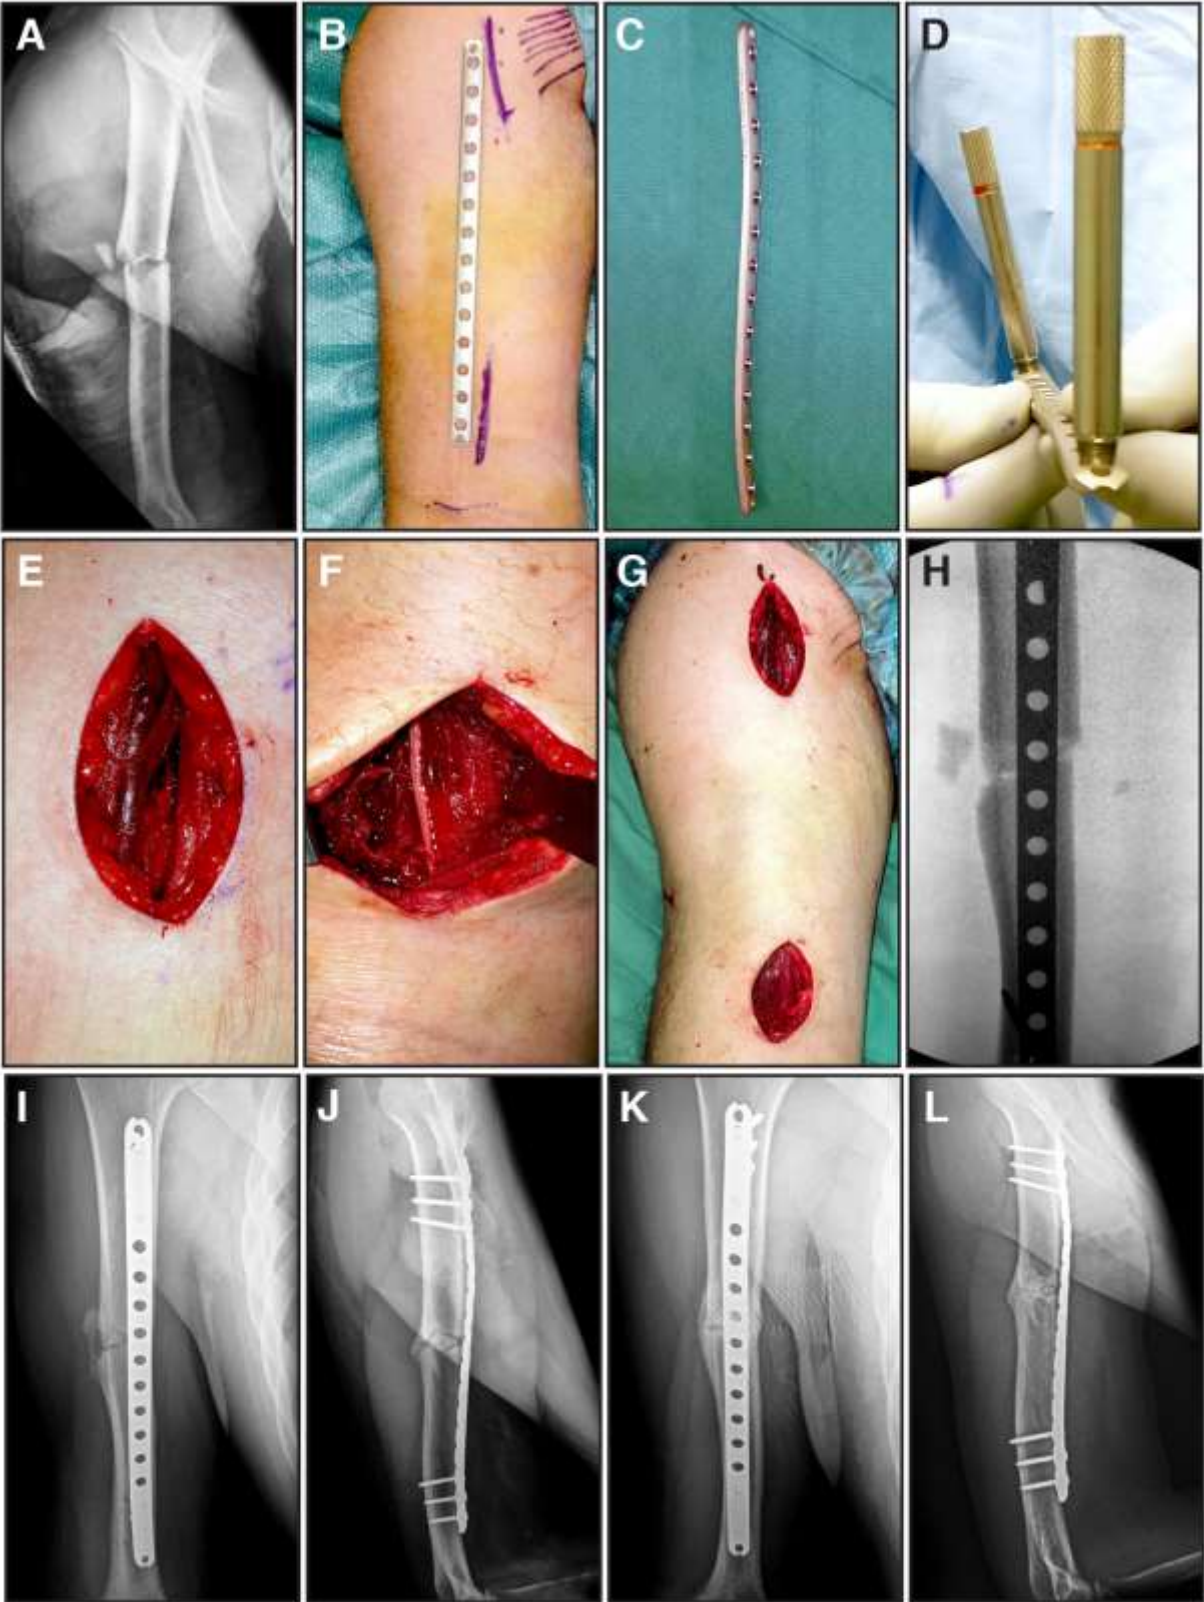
This 37 yo right hand dominant man sustained polytrauma in a motorbike accident. His injuries included a right floating elbow, with an ipsilateral both bone forearm fracture and (A) a closed mid-shaft right humeral shaft fracture; (B) a 14-hole locking compression plate was selected, with adequate length to span the fracture and provide sufficient mechanical control; (C) this plate was pre-contoured to closely match the normal anterior humeral cortical surface and serve as a better template for restoring anatomic alignment, by bending the plate with subtle opposing curves proximal and distal; (D) the plate is internally rotated 15-20° through its mid-portion, consistent with normal anatomy; (E) the proximal incision is 4-5 cm in length at the level of the pectoralis major insertion, preserving the cephalic vein, as an extension of the delto-pectoral approach; (F) the distal incision is 4-5 cm in length just proximal to the antecubital crease, and the lateral antebrachial cutaneous nerve of the forearm is identified beneath the biceps before bluntly splitting the brachialis; (G) a submuscular extra-periosteal tunnel is created to connect the two incisions; (H) a provisional closed reduction is performed prior to insertion of the plate, generally from distal to proximal; (I) AP radiograph at 8 weeks, demonstrating early callus, with minor varus <3°; (J) lateral radiograph at 8 weeks, confirming near anatomic alignment; (K) AP radiograph at 1 year, demonstrating mature bridging callus; (L) lateral radiograph at 1 year, confirming solid union.
